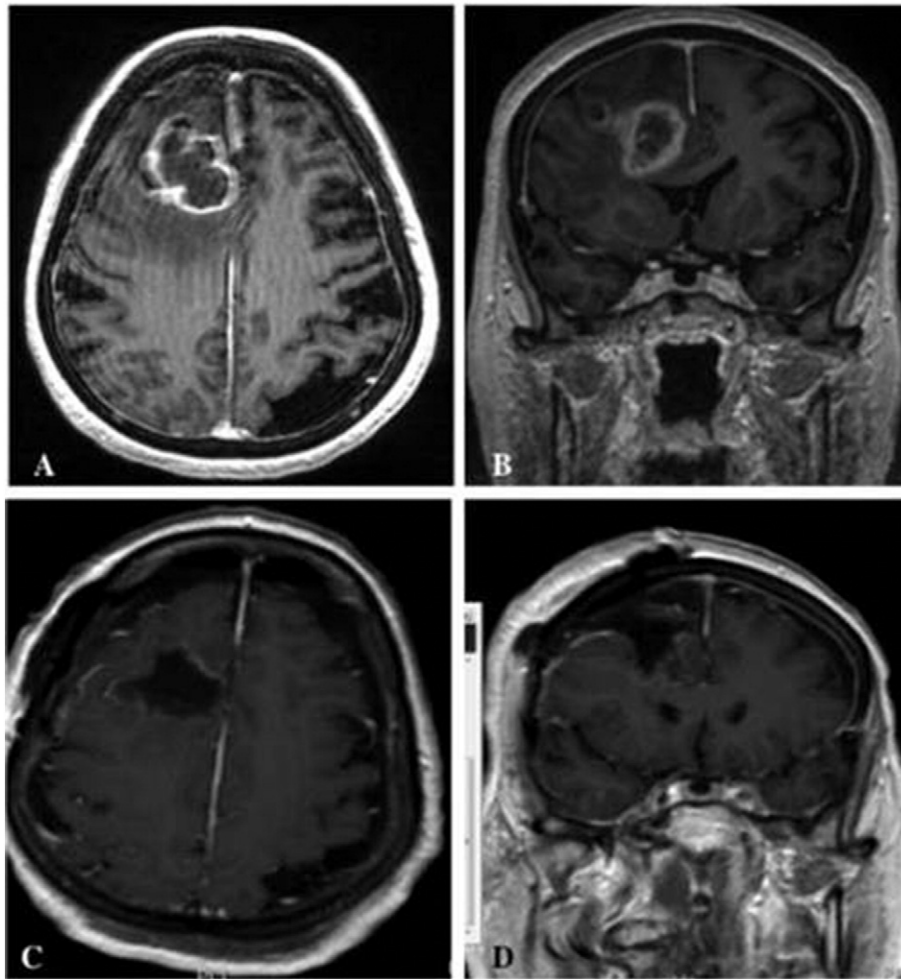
Pre and post operative brain MRI showing the complete removal of the brain tumor. No liquor or hemorrhagic collection is depicted.
